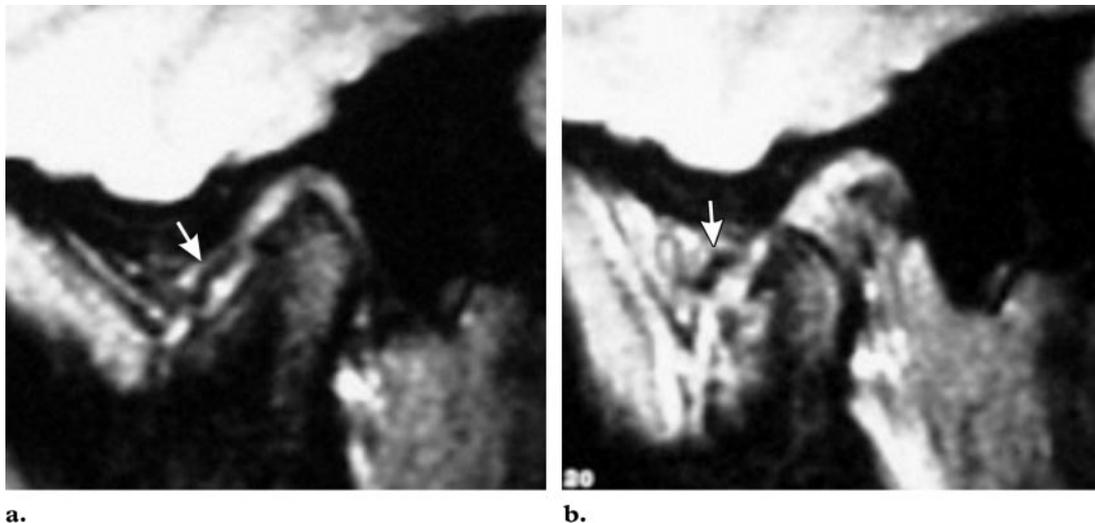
Normal disk mobility. (a) Sagittal oblique spin-echo proton-density-weighted MR image (closed-mouth position) shows a disk (arrow) in its normal position between the condyle and temporal bone and centered in the intermediate zone. (Reprinted, with permission, from reference 1.) (b) Sagittal oblique spin-echo proton-density-weighted MR image (open-mouth position) shows that the disk (arrow) has maintained its normal position during condylar movement. This interposition of the disk prevents abnormal contact between osseous joint surfaces.
